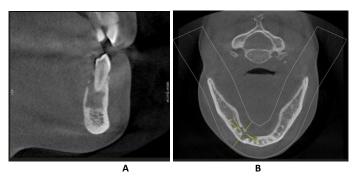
Cone Beam Computed Tomography a: Sagittal cross-section b: Axial cross-section
